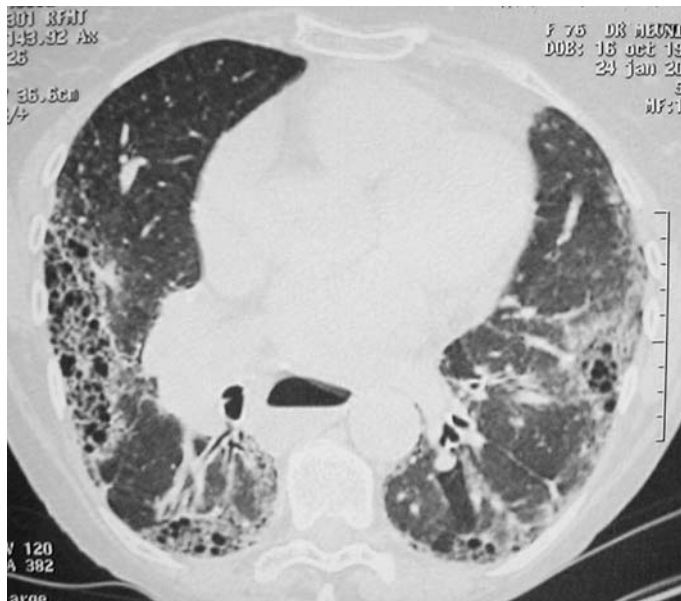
High resolution CT-scan at the lower lobes level. Severe interstitial lung disease and esophageal dilatation in a patient with systemic sclerosis
